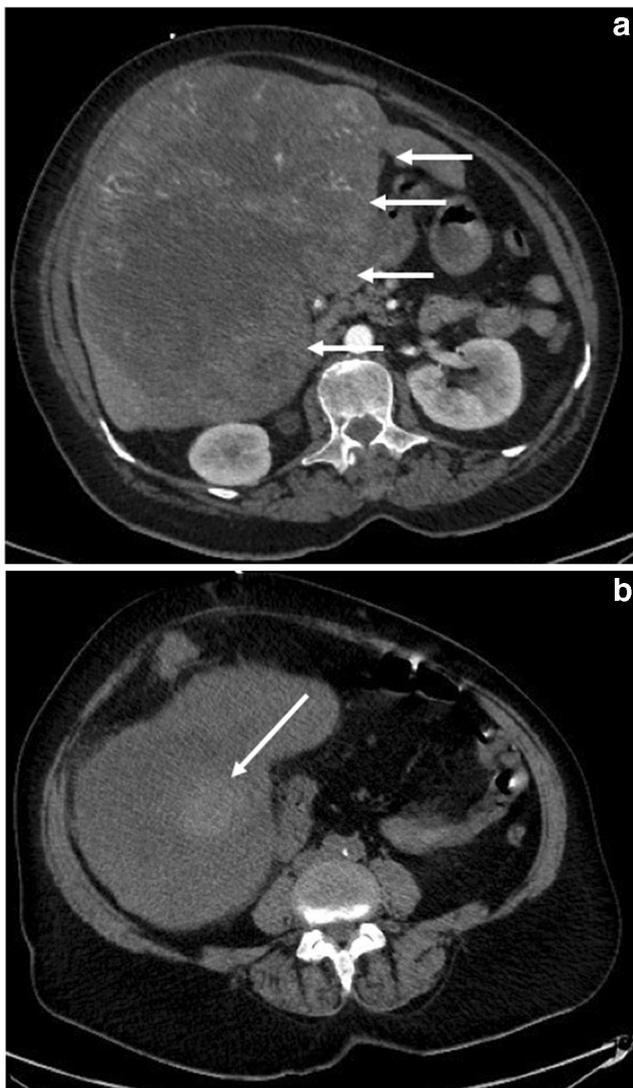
A 66-year-old female patient with 170-mm right hepatic mass confirmed as hepatocellular carcinoma (arrows, a). Pre-biopsy prothrombin time, platelet count, and serum creatinine level were 67% ($N = 70\text{--}100\%$), $409.10^9/L$ ($N = 150\text{--}400.10^9/L$), and $62 \mu\text{mol/L}$ ($N = 45\text{--}84 \mu\text{mol/L}$), respectively. Two 18-gauge core biopsies were performed. The patient underwent abdominal CT 3 days after biopsy for abdominal pain. CT showed liver hematoma (white arrow, b)
